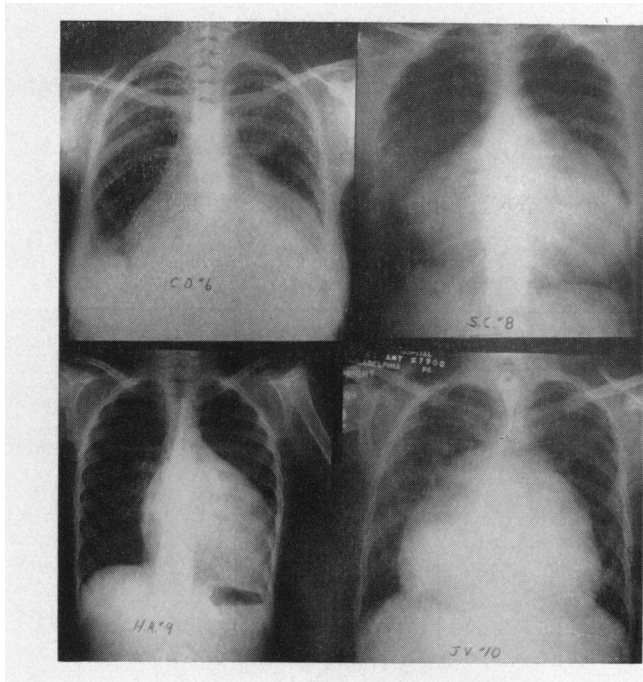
Postero-anterior X-ray of the chest. For interpretation, see text.
